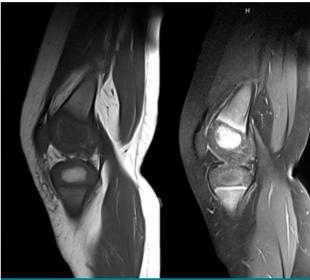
T1-T2 sagittal knee magnetic resonance images of the patient. The medial aspect of the distal epiphysis of the patient's left femur shows hypointense areas on T1A sequences and hyperintense areas on T2A sequences.
